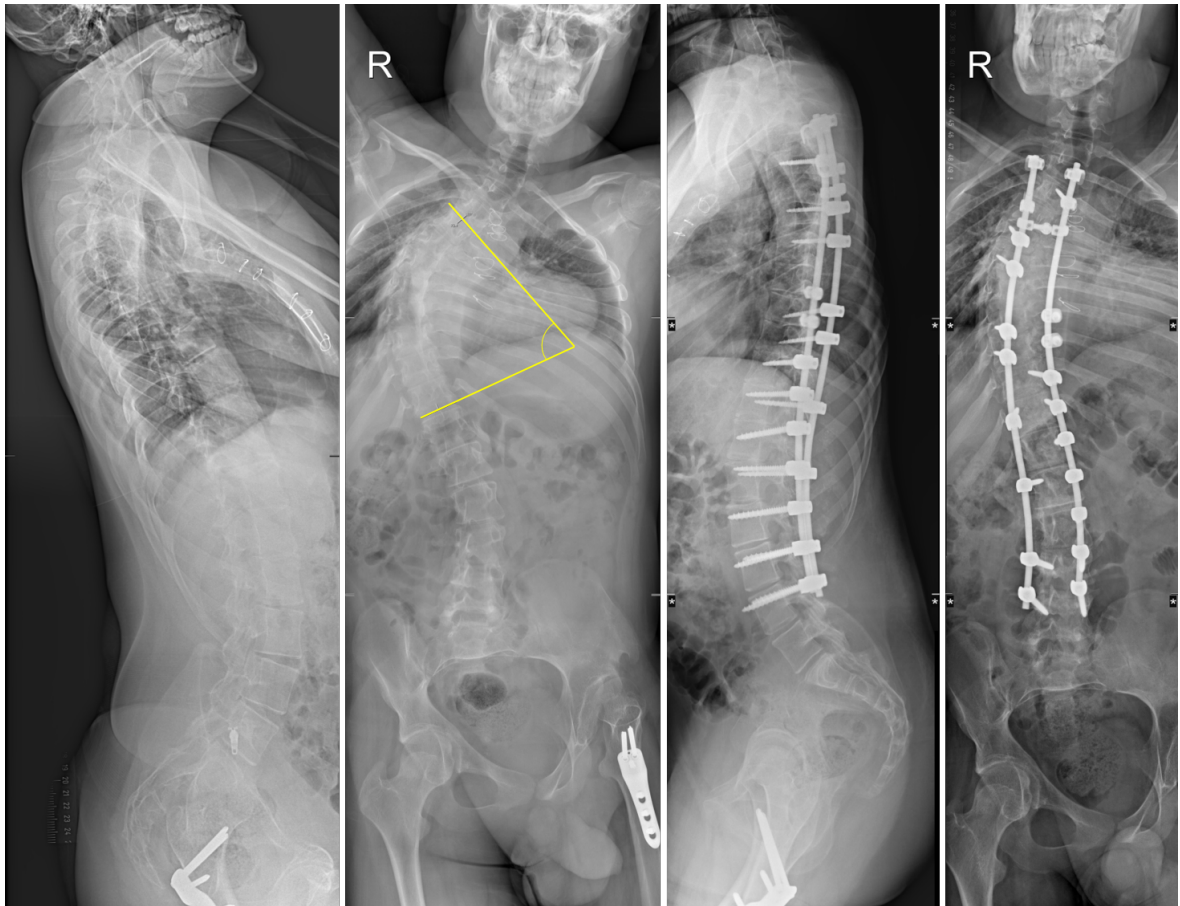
Pre- and post-operative X-ray images, described from left to right. In the left a AP view of the total spine is seen with a clear scoliosis (Cobb angle of approximately 75° , shown with the yellow lines). The second shows a sagittal view of the total spine is seen. The third and fourth image are 6 weeks post-operative X-ray's. The third is an AP view of the total spine in which a clear reduction of the scoliosis (Cobb angle of approximately 50°) is seen. In the fourth image a sagittal view of the total spine is seen.
